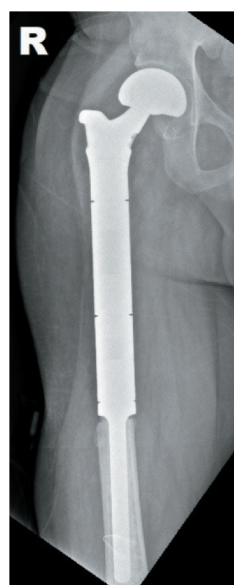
Radiograph of post right proximal femur replacement of patient. Note: created by the authors
